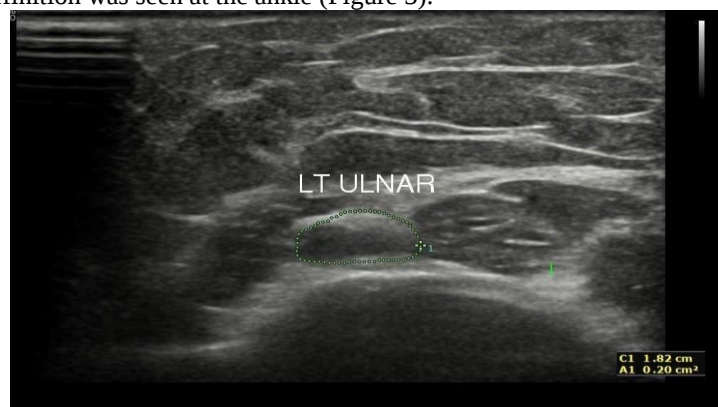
High-resolution ultrasonography of the left ulnar nerve at the elbow in a representative 60-year-old woman with Hansen's disease and peripheral neuropathy, showing diffuse nerve enlargement with a hypoechoic fascicular pattern and an increased cross-sectional area (direct-trace area 0.20 cm²), consistent with leprous neuritis.
